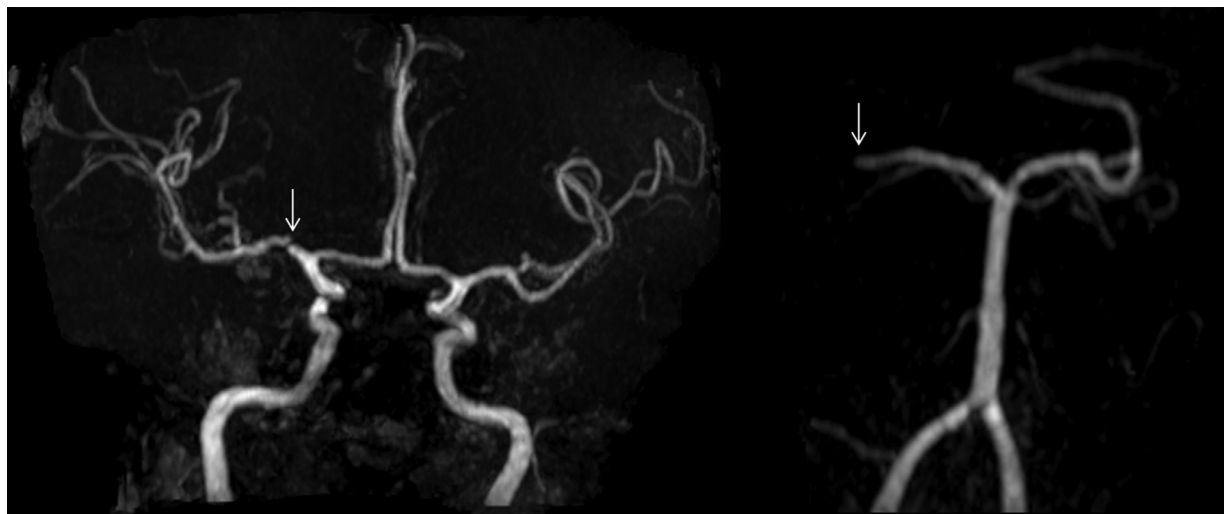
MRI angiogram evidenced severe stenosis in right middle (arrow in left image) and posterior cerebral artery (arrow in right image).
